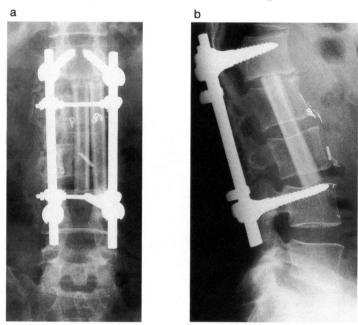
An antero-posterior view (a) and a lateral view (b) of postoperative X-ray.
